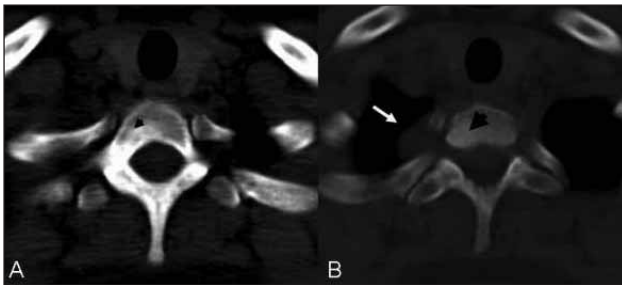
Thoracic axial CT showed a lesion extending from the right side of corpus to the pedicle and lamina without yielding an expansion and a lytic area measuring 1 x 0.7 cm was noted with a cortical destruction (black arrow) (A), IV contrast (gadolinium) was given and the extension of the lesion from the inferior lying neural foramina to the extrapleural fat tissue without well demarcated borders was visualised and reported as a non-specific soft tissue mass (white arrow) (B).
